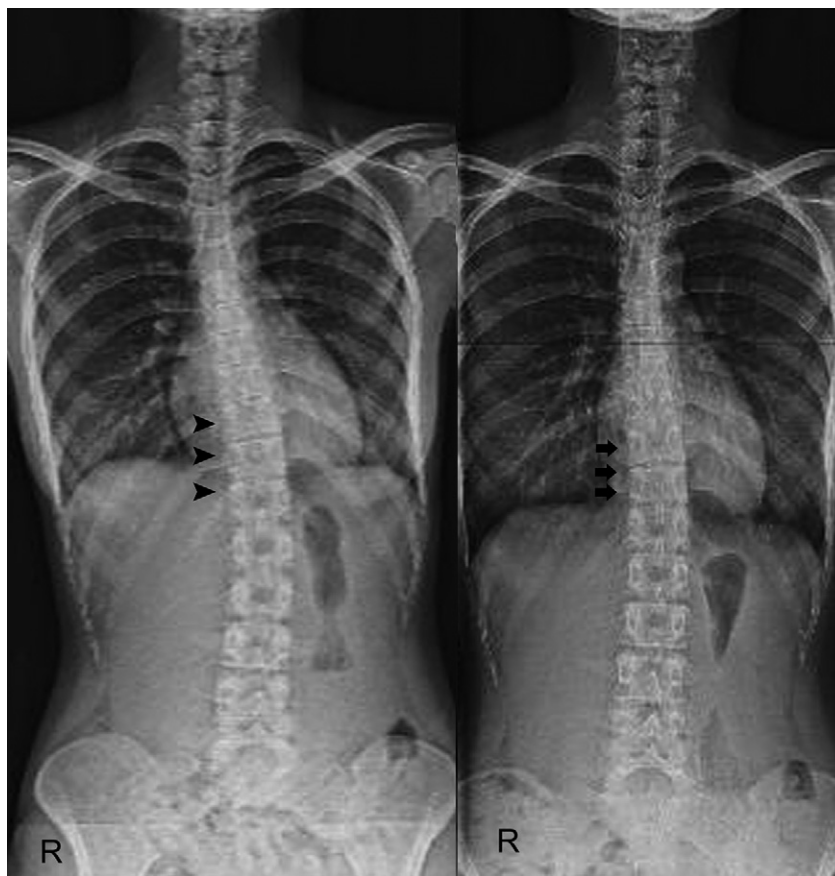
Pre- and postoperative X-rays. (Left) Preoperative anteroposterior plain X-rays demonstrating the thoracic curve (arrowheads). (Right) Anteroposterior plain X-rays, made 2 months postoperatively, showing the improvement of the scoliosis (arrows).
